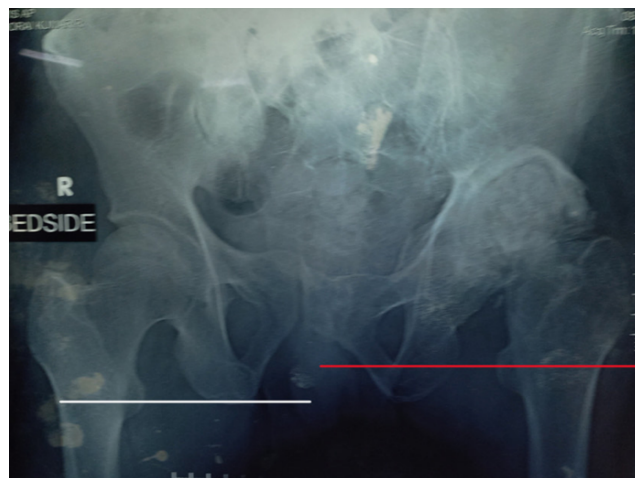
Pelvis AP x-ray taken 8 weeks post application of skeletal traction showing further correction of pelvic obliquity with gradual descent of proximal femur complex
